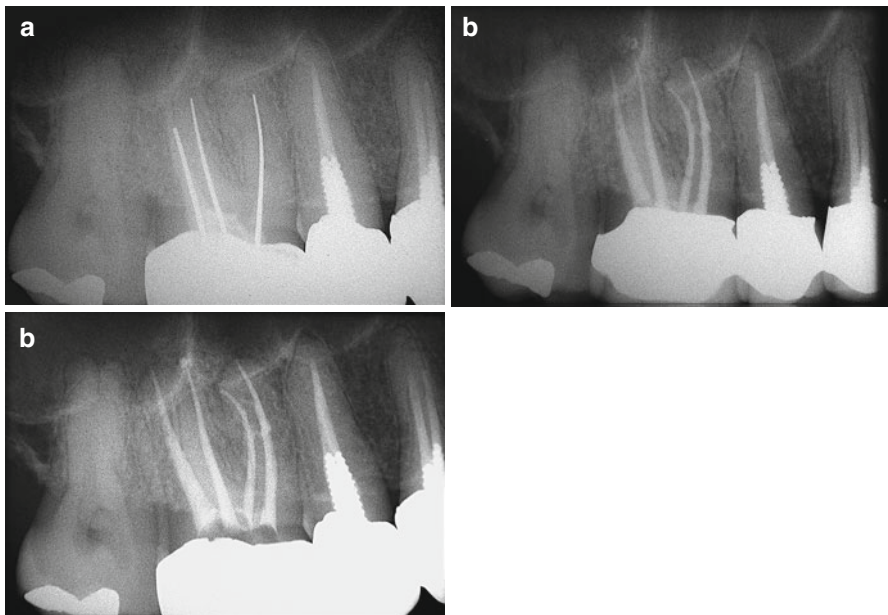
(a) Preoperative radiograph. Right maxillary first molar with insufficient endodontic treatment. (b) Postoperative radiograph after retreatment. The mesiobuccal root has two independent canals: MB1 and MB2. (c) Radiographic follow-up after 6 months
